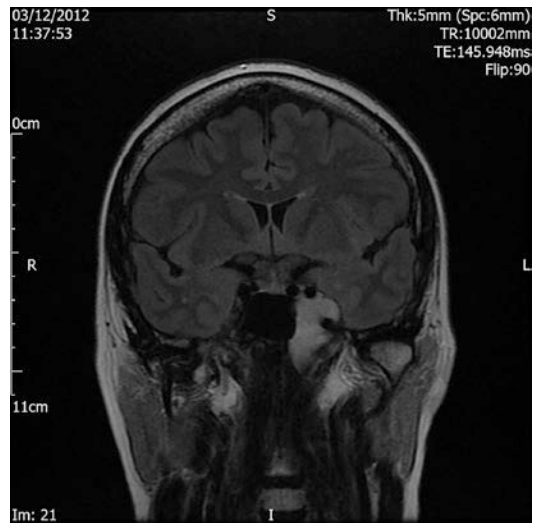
Coronal T1 weighted MRI scan demonstrating a lesion in the left sphenoid sinus wrapped around the left Internal-carotid artery
